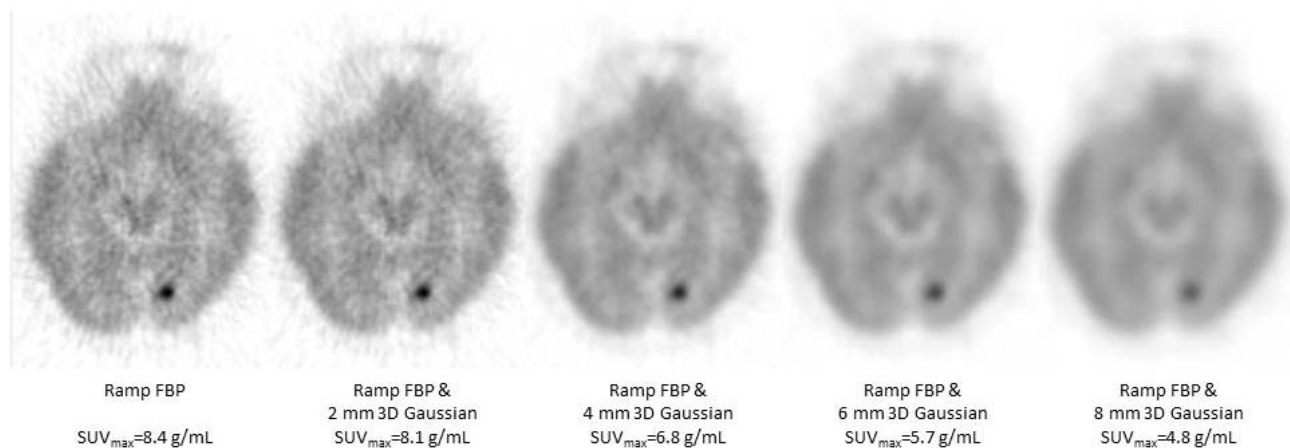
Transverse slice from an FDG brain study showing the effect of image smoothing on SUV_{max} . All images are shown in a fixed inverse greyscale SUV from 0 to 8.
